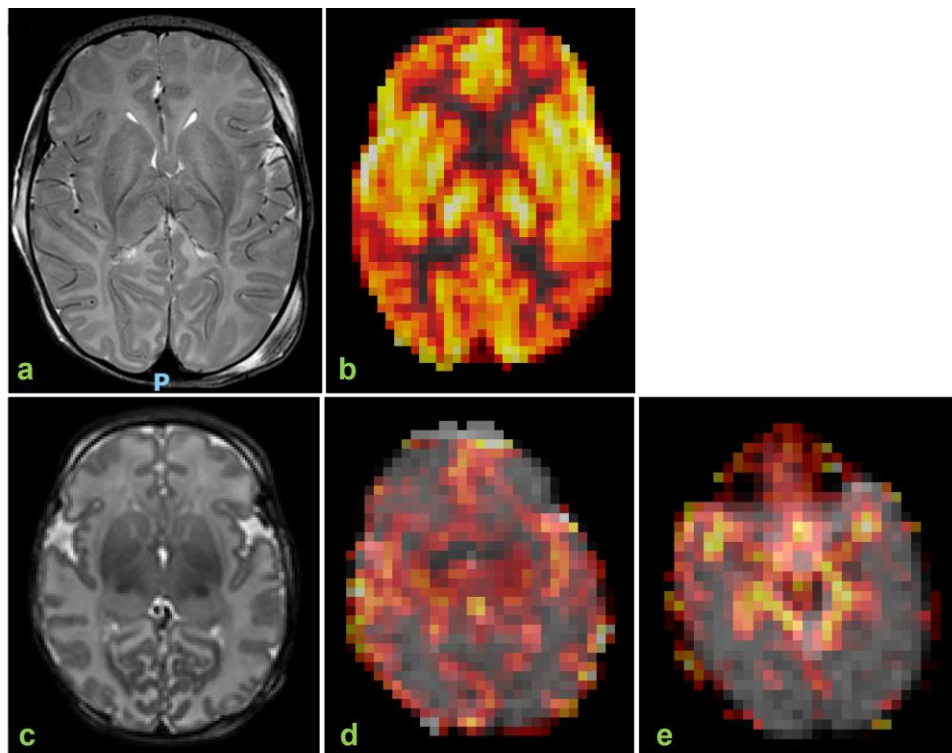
MRI Images and rCBF map acquired using pcASL from 2 infants. Grading colour scale, where black is equivalent to CBF of 0ml/100g/min, grades up to red (15-35ml/100g/min), orange (35-50ml/100g/min), yellow (50-70ml/100g/min) and white (>70ml/100g/min).
